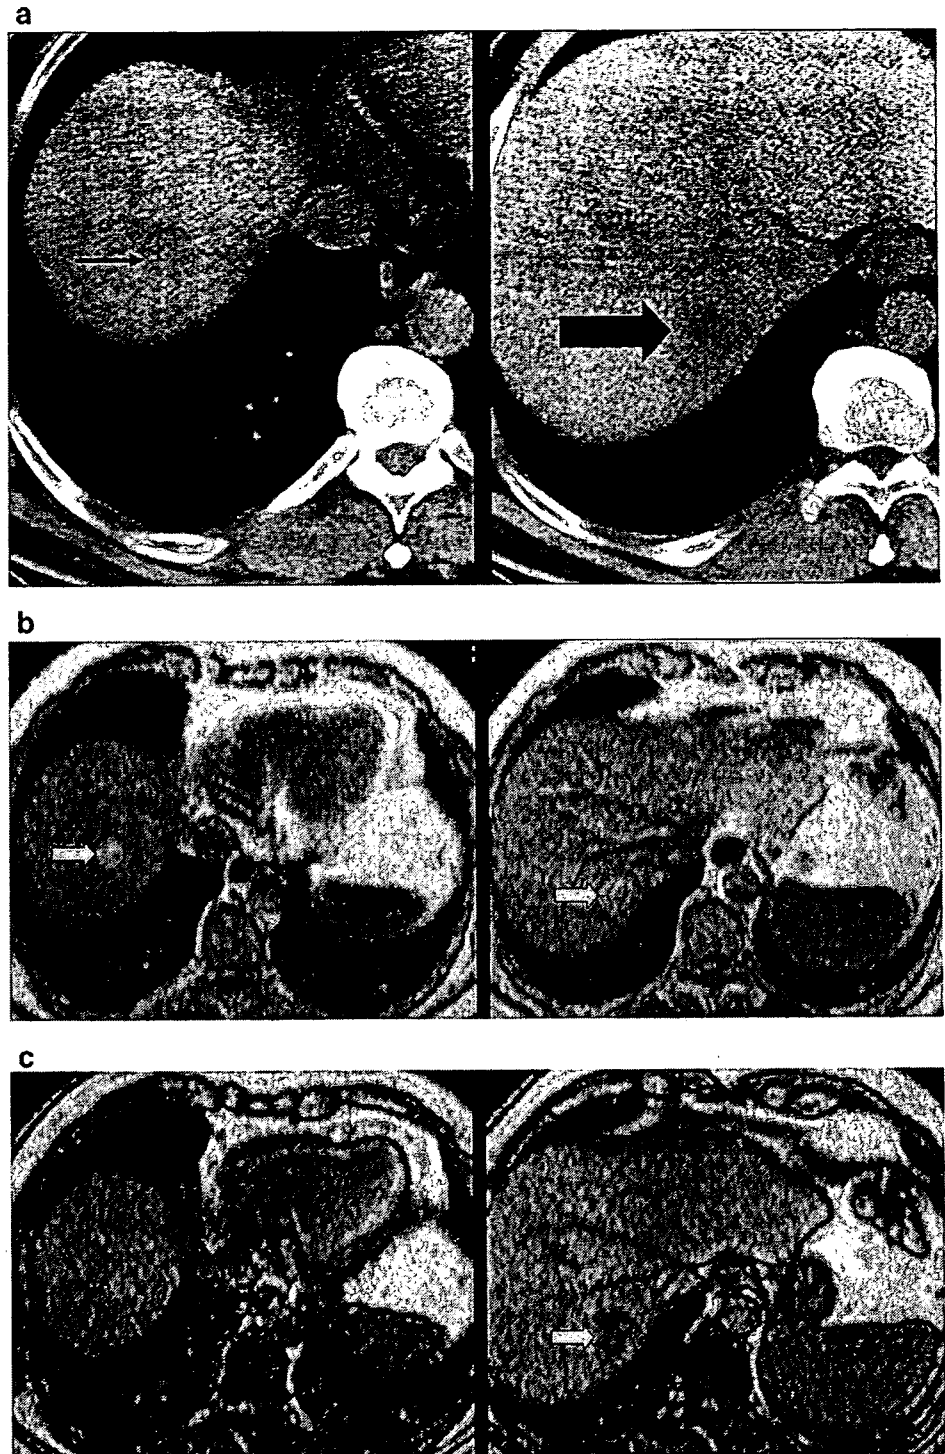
Two fat-containing early HCCs in a patient with cirrhosis due to chronic viral hepatitis B. a Unenhanced CT demonstrates two low-density lesions in segments 8 (*small arrow*) and 7 (*large arrow*). The lesions became isodense in the arterial phase and remained so in the portal venous phase (not shown). On in-phase T1-weighted gradient-echo sequence (b), the lesions are hyperintense (*arrows*), while on out-of-phase images (c), they lose signal, becoming iso- and hypointense (*arrow*), respectively
